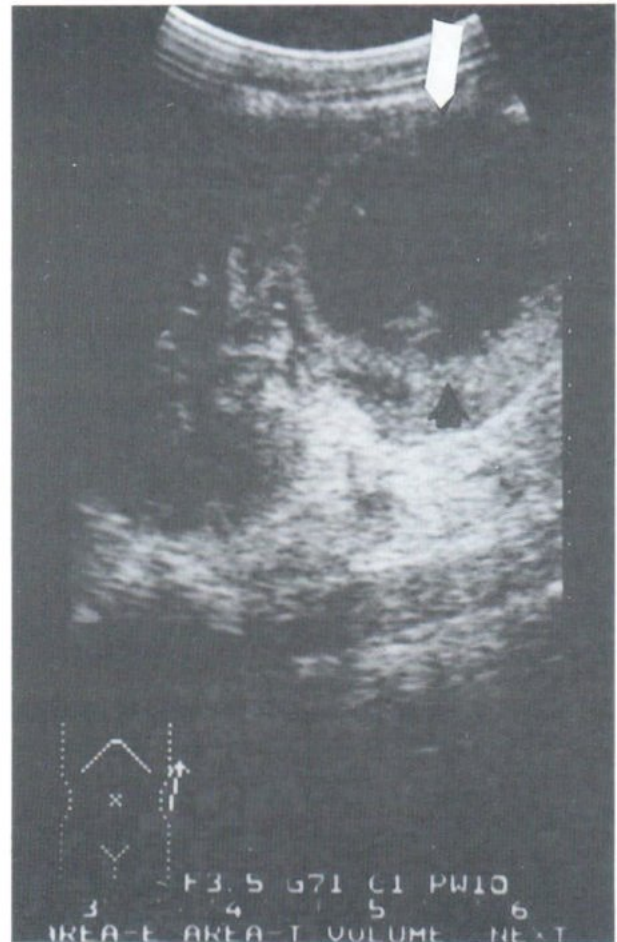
Longitudinal ultrasound image of the left kidney shows a hypoechoic mass in the lower pole of the left kidney.
